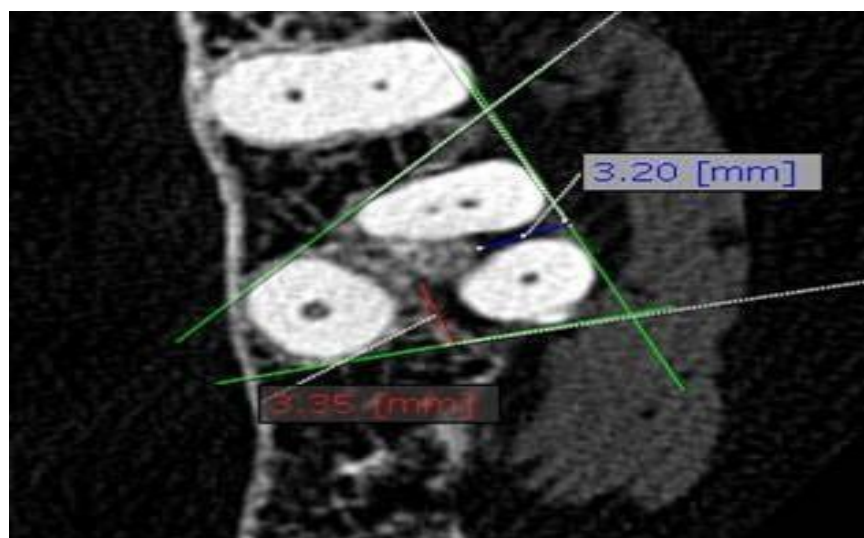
CBCT axial cut showing measurement of trifurcation bone loss: disto palatal class II FI (3.35 mm> 2mm) and mesiodistal class II FI (3.20) mm of upper left first molar as class II horizontal bone destruction extending deeper than 2 mm but less than 6 mm into the furca.
